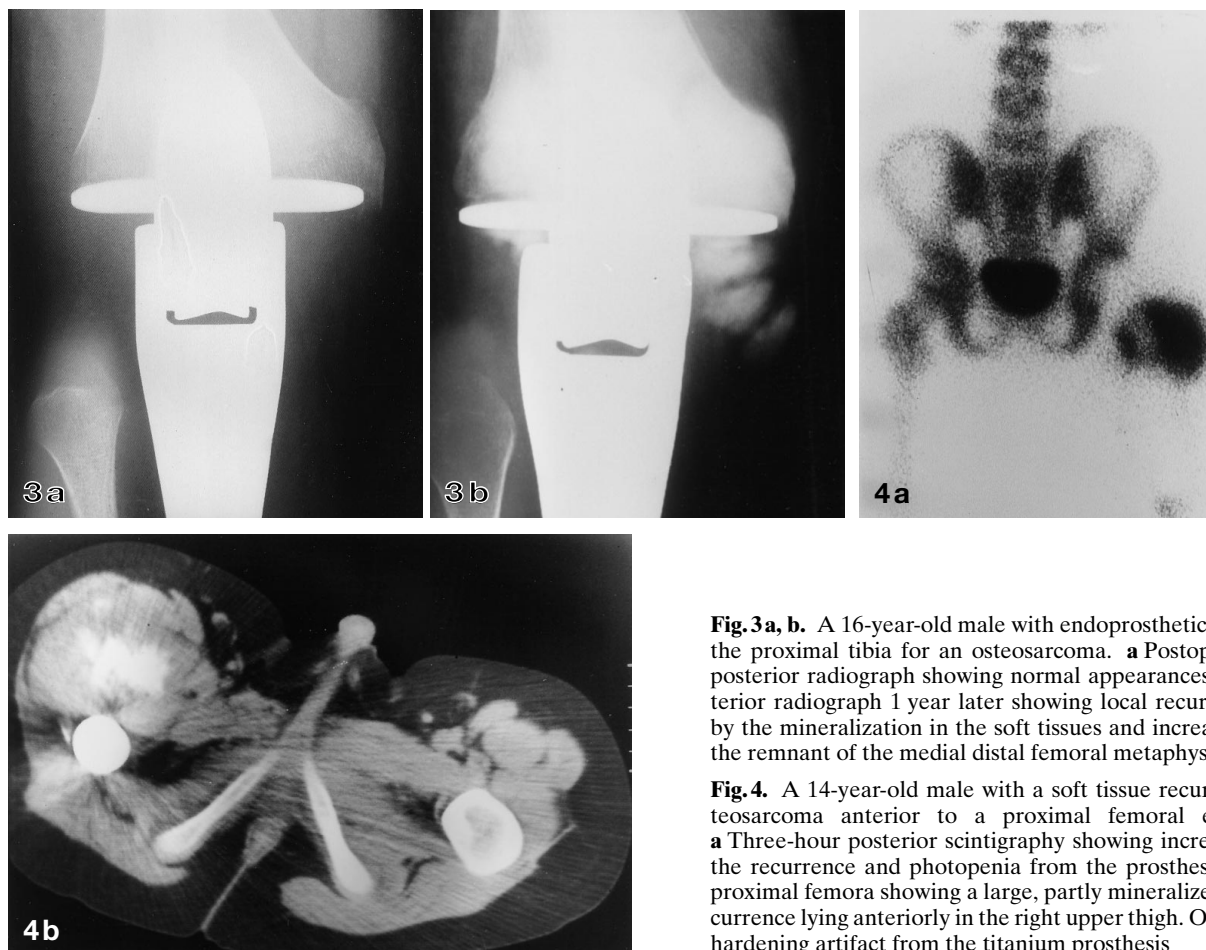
A 16-year-old male with endoprosthetic replacement of the proximal tibia for an osteosarcoma. a Postoperative anteroposterior radiograph showing normal appearances. b Anteroposterior radiograph 1 year later showing local recurrence indicated by the mineralization in the soft tissues and increased sclerosis in the remnant of the medial distal femoral metaphysis
